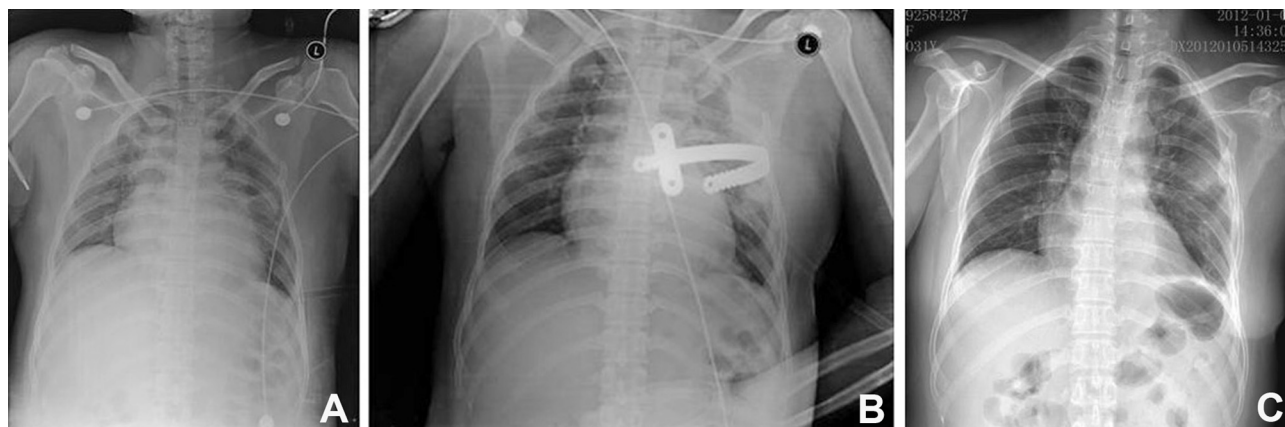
(A) Presurgical anteroposterior plain radiographs. (B) Follow-up plain radiographs, 4 days after surgery. (C) Two days after the bars were withdrawn.
